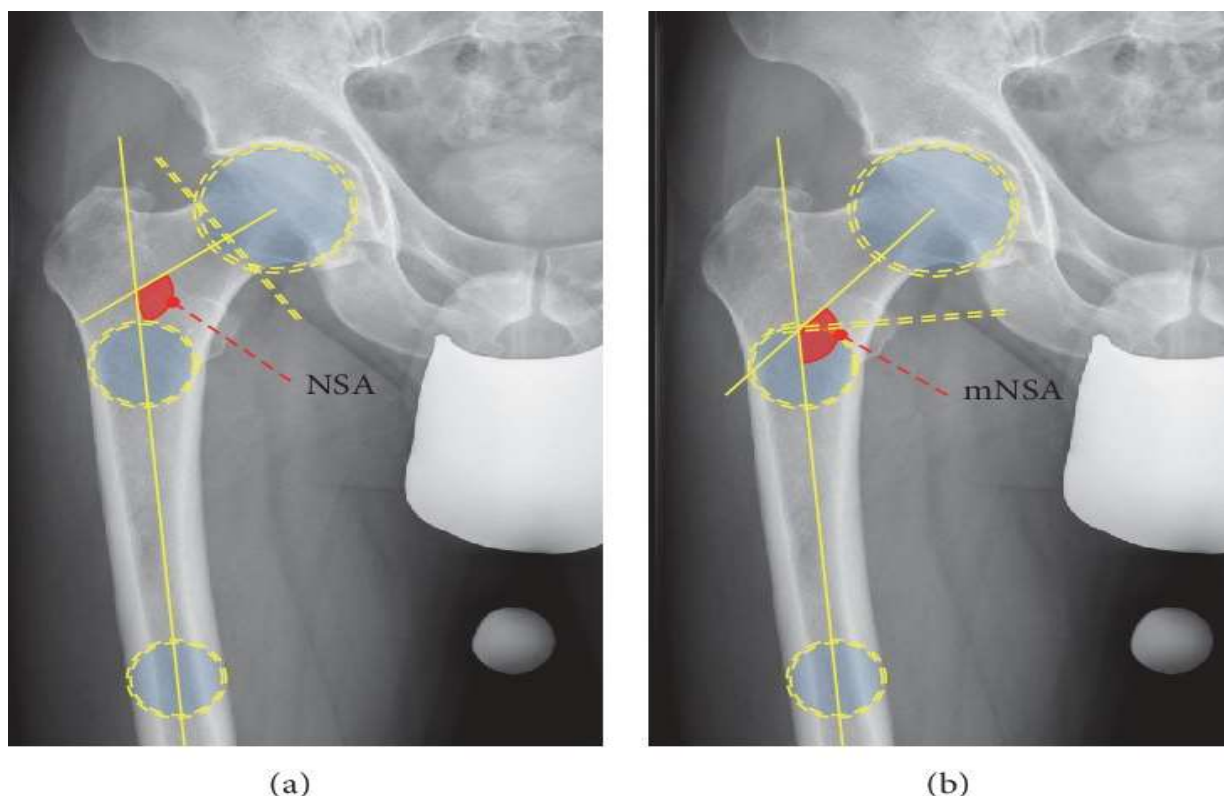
(a) Normal neck shaft angle, CT image (b) The modified NSA of femur, CT image
